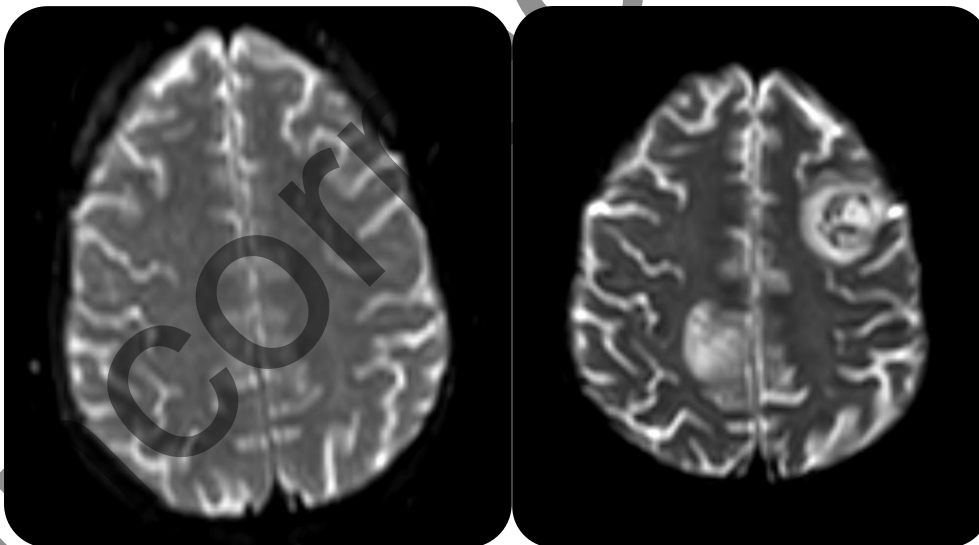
Comparative axial diffusion-weighted MRI images of the brain. (Left) Initial imaging shows no abnormal signal intensity or structural lesions. (Right) Follow-up MRI 17 days later demonstrates new, well-defined ring-enhancing lesions in both cerebral hemispheres, consistent with evolving cerebral fungal abscesses. The interval development of these lesions correlates with the patient's neurological decline and supports the diagnosis of disseminated invasive aspergillosis.
